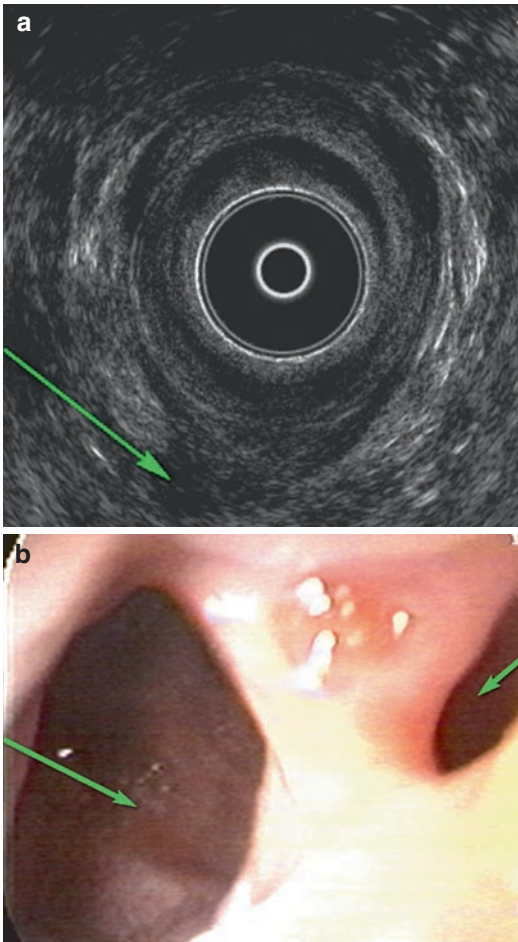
(a) Endorectal ultrasound of a rectal duplication (arrow), (b) endoscopic appearance of the duplication (arrow) with conventional lumen (block arrow).
